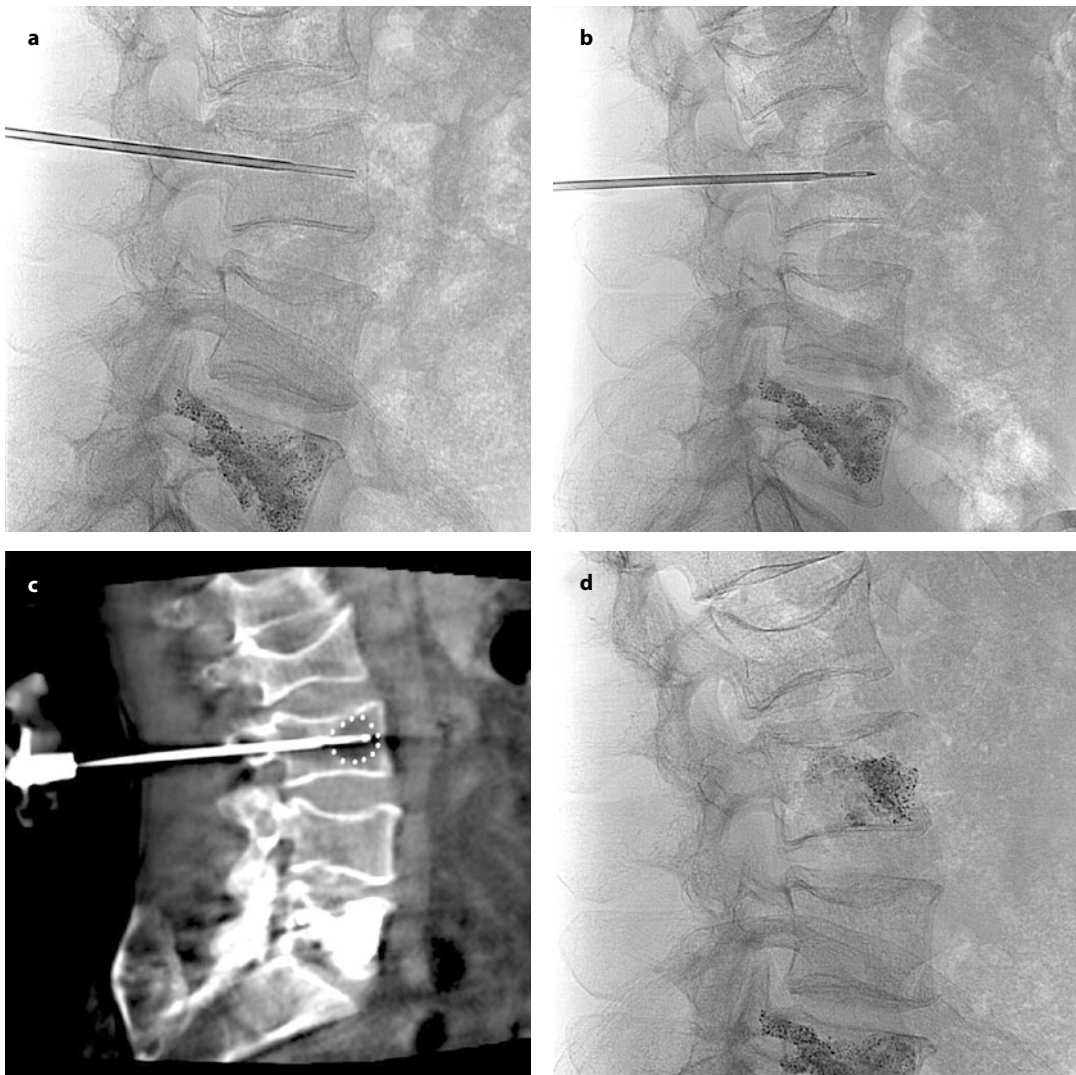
L3 treatment of a metastatic lesion in a 50-year-old male with colorectal cancer. After biopsy (a), a 17-G cryoprobe was inserted coaxially through the same 13-G needle (b) and fluoro-CT-guided cryoablation undertaken (ice ball is shown as a *dotted oval shape*) (c). This was followed by cement injection to ensure vertebral stability; lateral fluoroscopic view shows good cement impregnation of the cryoablated vertebral body (d)
